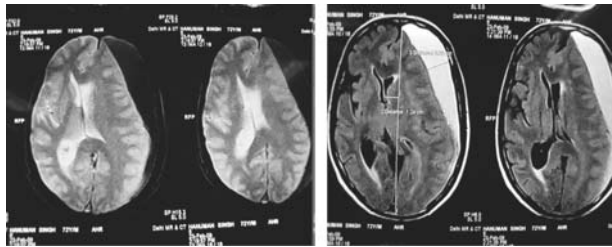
MRI Head (T1WI & T2WI) showing unilateral CSDH
